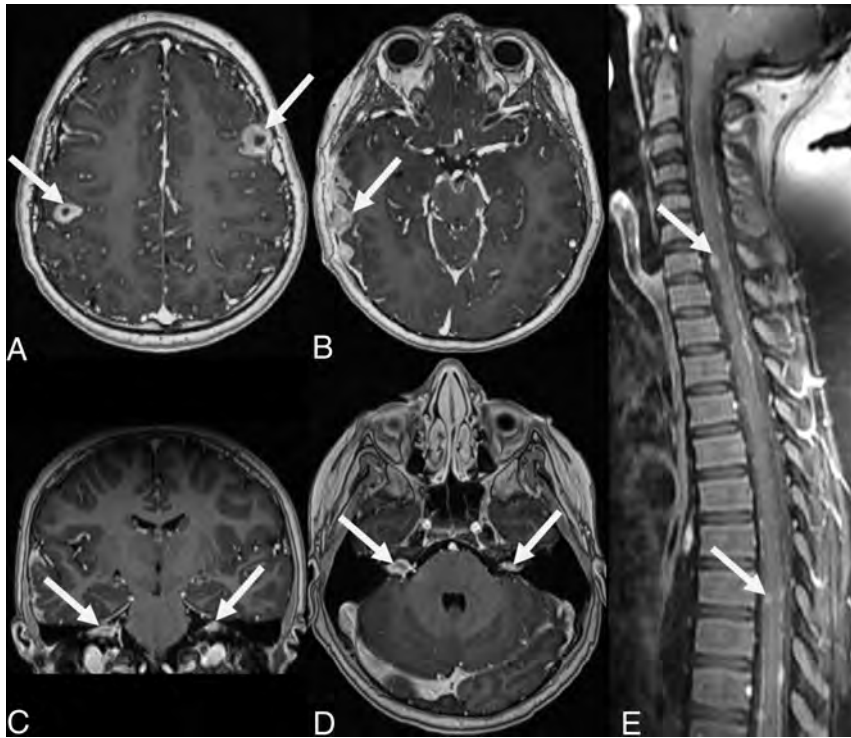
MR images obtained in a 10-year-old boy with pathology-proven multifocal JXG with leptomeningeal brain and spine involvement. The patient presented with progressive right-ear pain and erythema and decreased hearing and right-sided facial nerve palsy along with headaches. Axial (A, B, and D) and coronal T1+CE-weighted (C) MR images of the brain. E, Sagittal T1+CE-weighted fat-suppressed MR image of the spine. For example, 2 centrally necrotic, peripherally contrast-enhancing lesions are noted within both cerebral hemispheres (arrows in A). In addition, nodular contrast enhancement involving the leptomeninges of the right temporal lobe (arrow in B) and contrast enhancement within both internal auditory canals (arrows in C and D) are shown. Sagittal T1+CE-weighted images of the spine depict increased contrast enhancement of the leptomeninges (“sugar coating”), partially with nodular components, most obvious at the C7 and T8 level (arrows in E).
